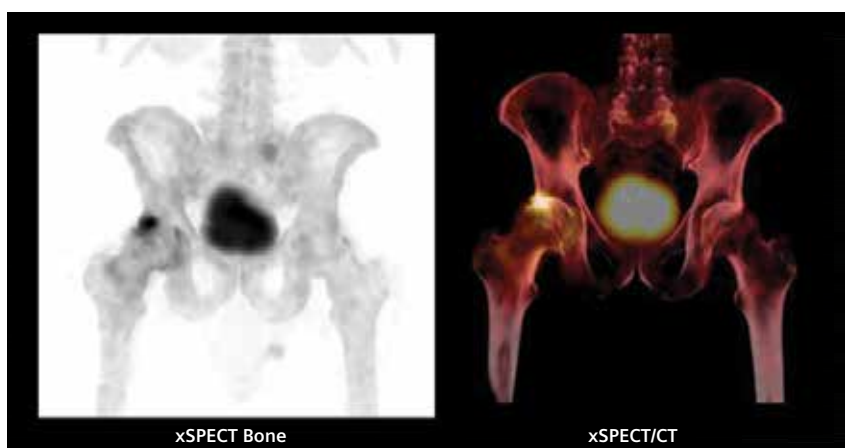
MIP of xSPECT Bone and volume rendering of xSPECT/CT data show focal uptake of ^{99m}Tc MDP at the antero-superior aspect of the acetabulum and the adjacent anterolateral femoral head. The contralateral acetabulum appears normal.
